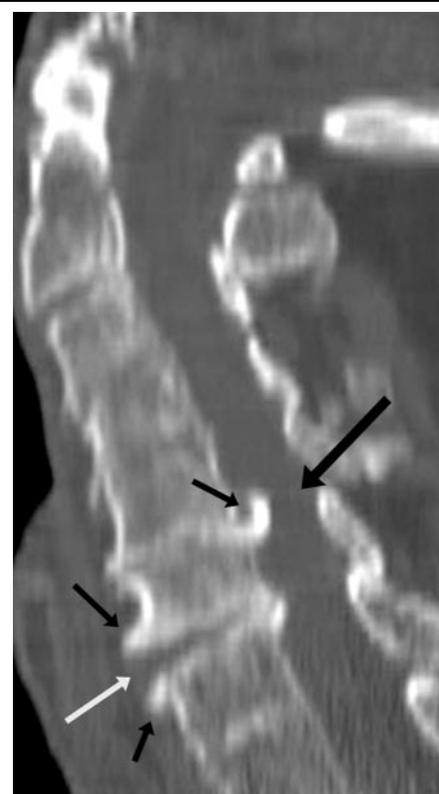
(a) Sagittal multi-detector row CT scan of the cervical spine. This image was initially interpreted as showing normal alignment with the exception of degenerative changes including anterior and posterior osteophytes (small black arrows) and associated spinal canal narrowing at C5-6 (large black arrow). At retrospective evaluation of the image, widening of the interspace was detected anteriorly at the C6-7 level (white arrow). (b) Sagittal T2-weighted MR image (4000/87, 32.0 × 32.0-cm field of view, 512 × 512 matrix) shows anterior widening of the C6-7 level with disruption of the anterior longitudinal ligament (thin black arrow), prevertebral edema (thick black arrow), and increased T2-weighted signal intensity in the C6-7 intervertebral disk (thin white arrow), a finding that is consistent with a diskoligamentous injury. In addition, the image also demonstrates a disk bulge at C2-3 with a cord contusion (thick white arrow).
